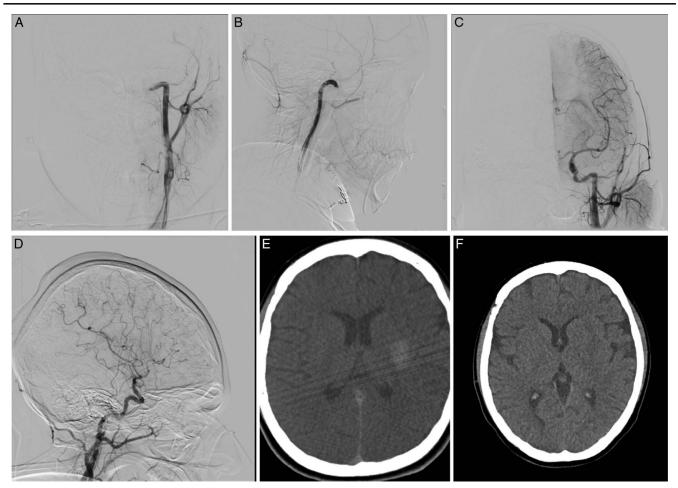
(A, B) Digital subtraction angiography (DSA) showed left distal internal carotid (ICA) occlusion in PA and lateral view of ICA. (C, D) Post-thrombectomy angiography of left ICA in PA and lateral views show complete revascularization of left ICA and MCA territories. (E) Immediate post-thrombectomy computed tomography scan shows hyperdensity in the left basal ganglia due to contrast extravasation. (F) Disappearance of contrast extravasation 12 h after thrombectomy. MCA, middle cerebral artery; FLAIR, fluid-attenuated inversion recovery.
